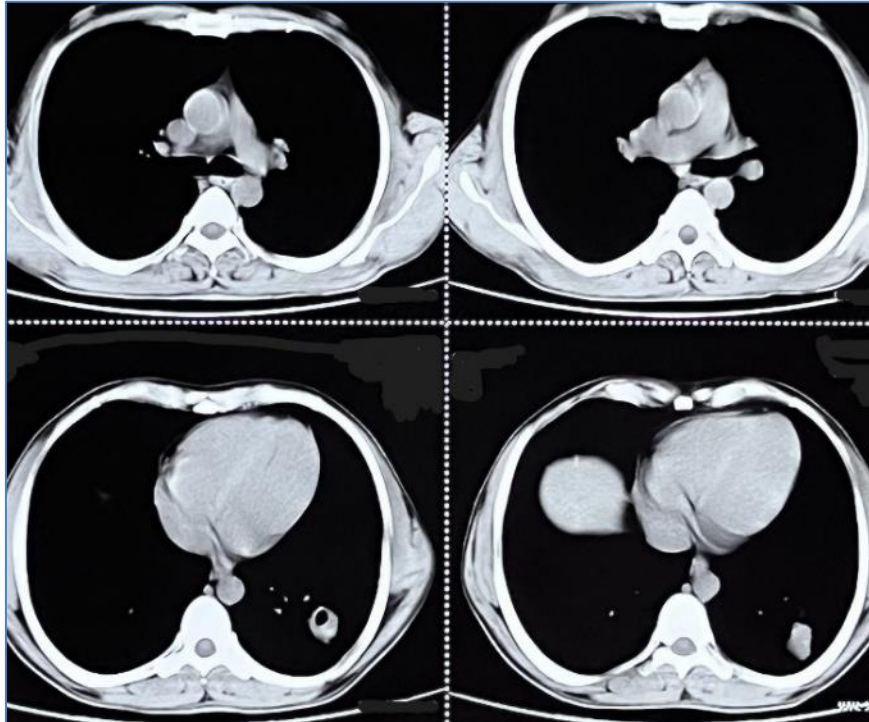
HRCT thorax mediastinal window showing eccentric cavitation without air fluid level and calcification in round pneumonia in left lower lobe
